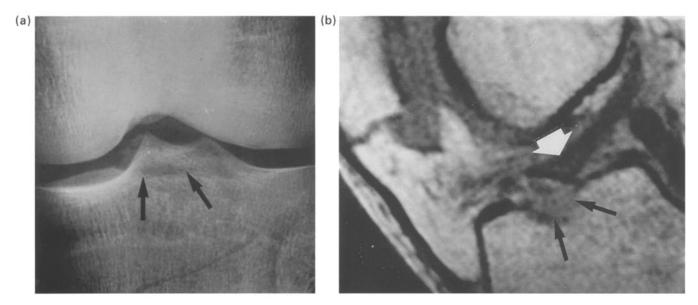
Plain film (a) shows a fracture of the anterior tibial plateau (black arrows). On sagittal T_1 -weighted spin-echo sequence (b), an enlargement of the distal portion of the anterior cruciate ligament (white arrow) induced by the traumatic event is shown.
